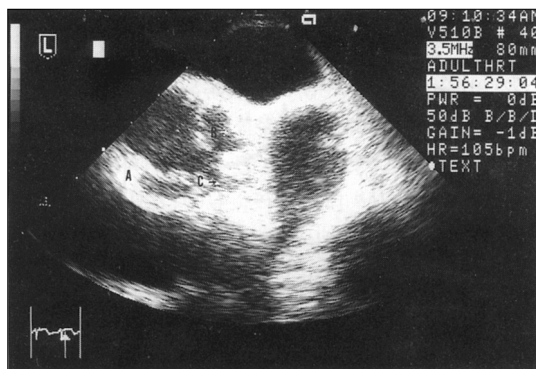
A transesophageal echocardiographic basal shortaxis view revealed that the right coronary artery originated from the left coronary sinus and ran parallel anterior to the left main coronary artery(A. aorta, B. the left main coronary artery, C. the right coronary artery).
